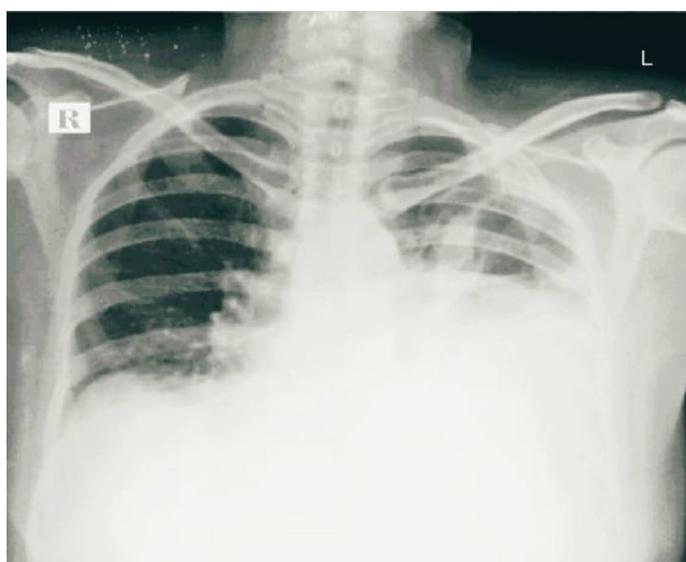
Chest X-Rays during hospitalisation showing BL pleural effusion.
